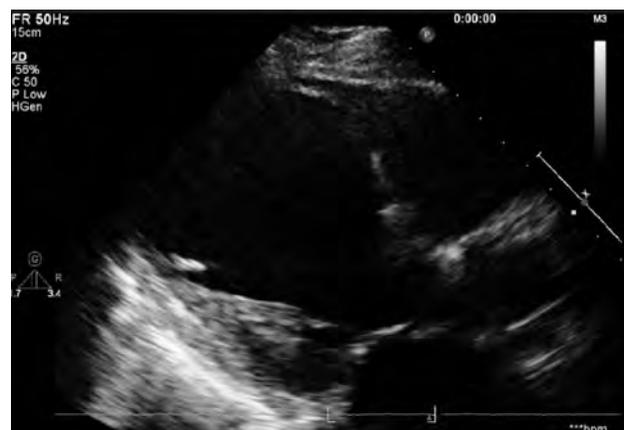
Ventricular septal defect and left ventricular apical aneurysm (a parasternal long-axis view)
